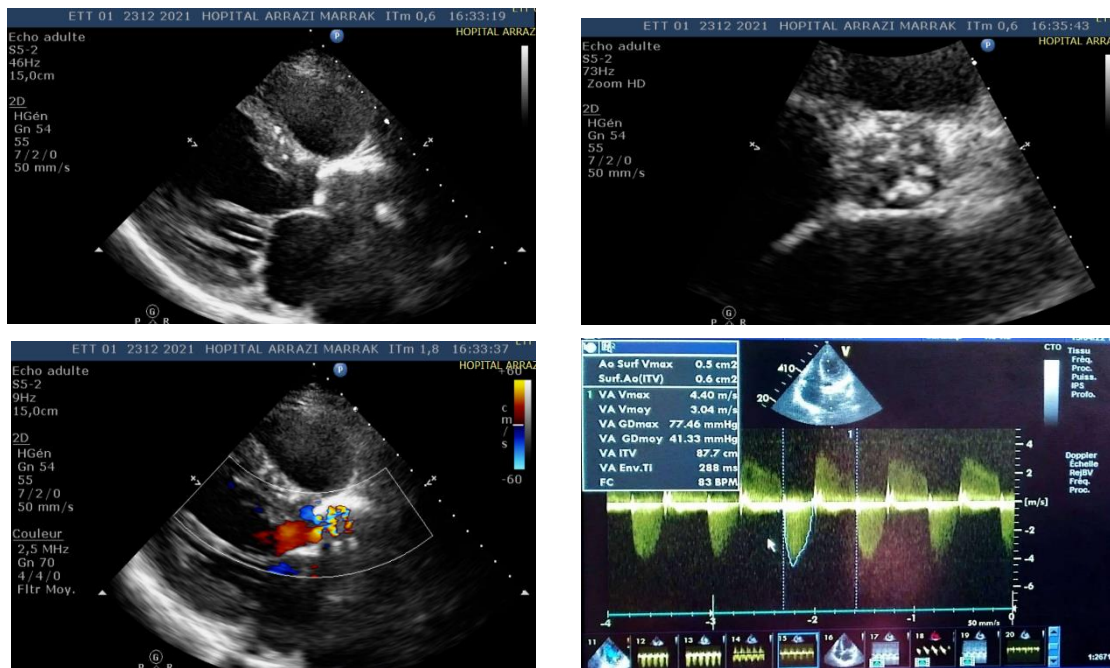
Echocardiography demonstrates a heavily calcified aortic valve with tight aortic stenosis (valve area 0.5 cm², mean gradient 41 mm Hg) and moderate aortic insufficiency.
